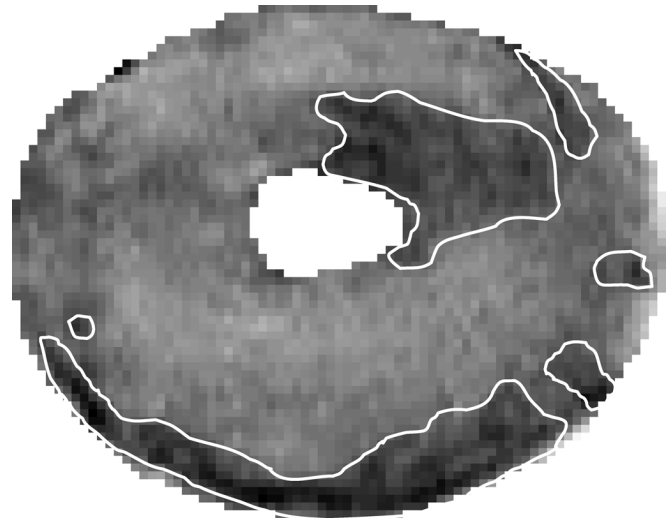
USPIO-enhanced cardiac MR image where the dark pixels are segmented. Dark pixels correspond to the locations of USPIO-labeled abnormal cells.
